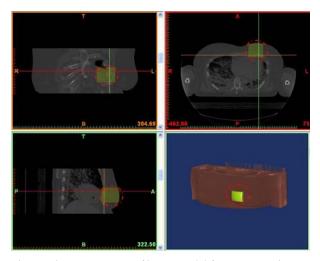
Choose some part of breast model from CT-scan image
